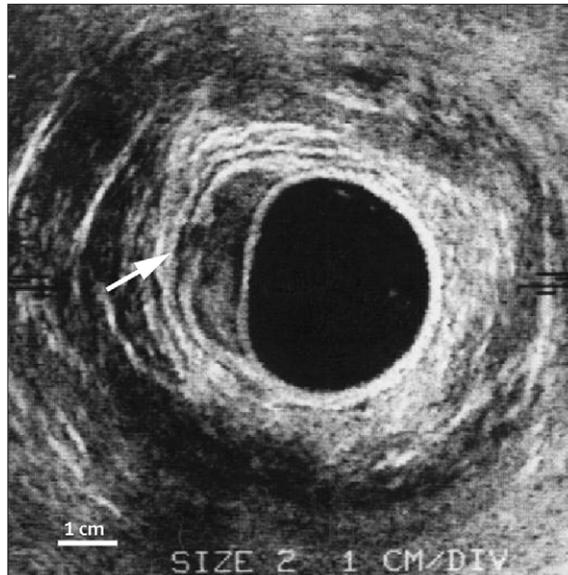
Endorectal ultrasound of rectal cancer
